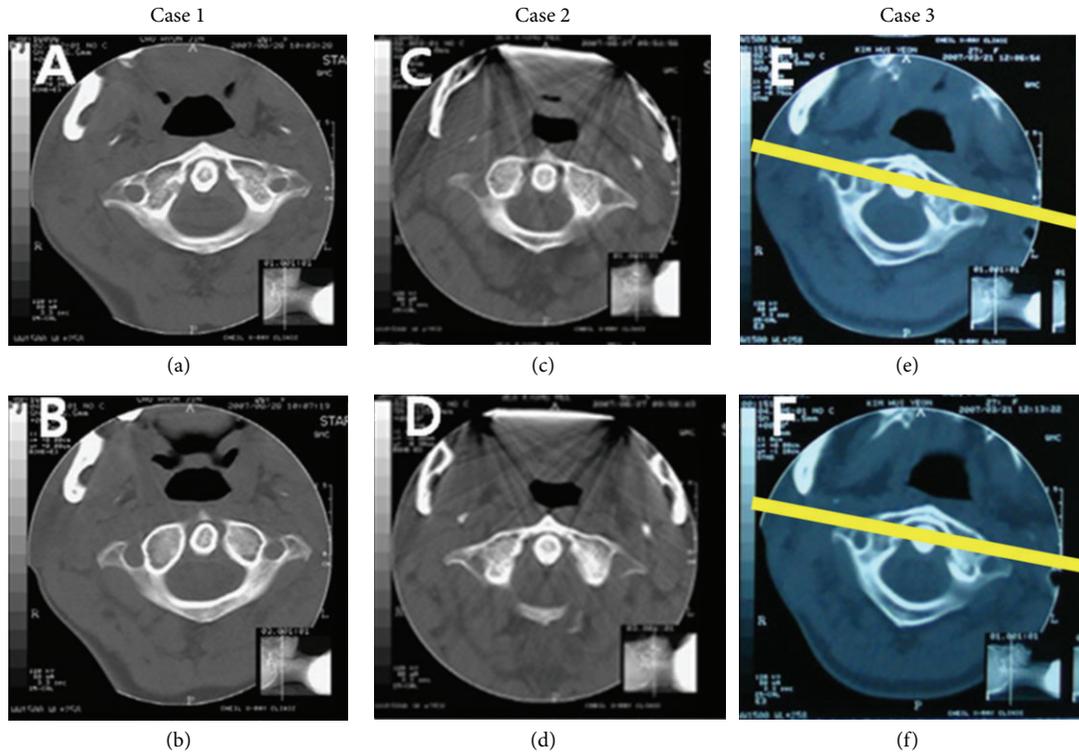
Exemplary CT image of 3 patients. Comparison shows an immediate change in the degree of rotational misalignment in the atlas while wearing the oral appliance. (a), (c), and (e) CT image while not wearing the oral appliance. (b), (d), and (f) CT image while wearing the oral appliance. Lines drawn over figures (e) and (f) indicate ameasuring method of atlas rotation angle with a line passing the anterior border of foramen transversarium of the atlas.
